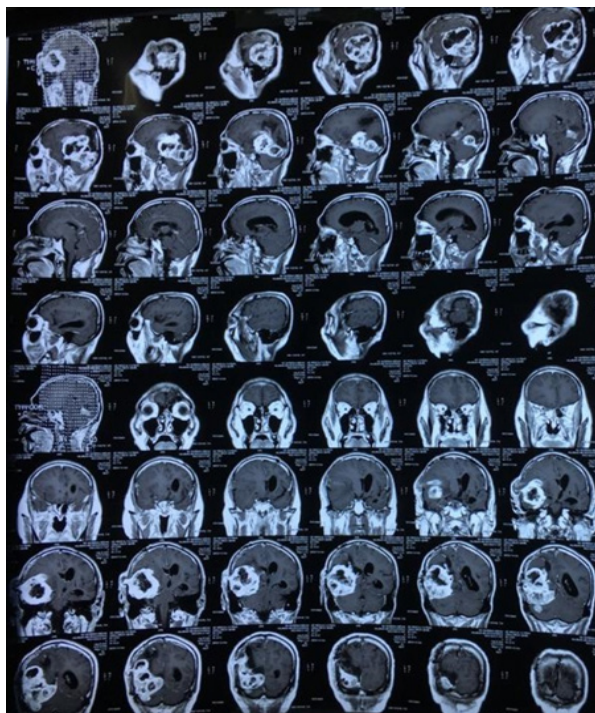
Preoperative MRI Showed Cerebral Tumor on the Right Temporoparietooccipital Region that Extend to Right Cerebellum with Extracranial Protrusion from Craniotomy Remnant
